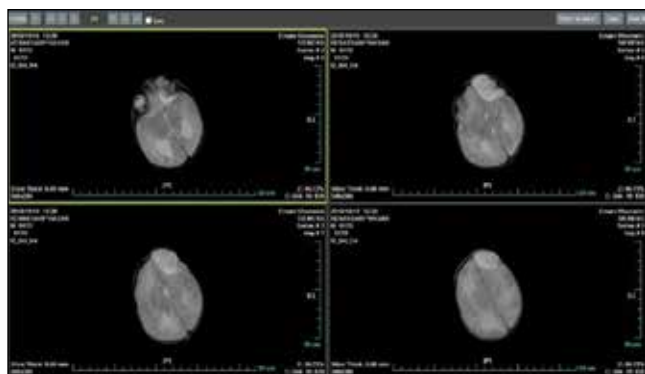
Brain MRI of the neonate from well-defined fluid-filled mass in the left frontal part of the head overcoming on the left eye was suggested to occur because of be left frontal lobe atrophy
